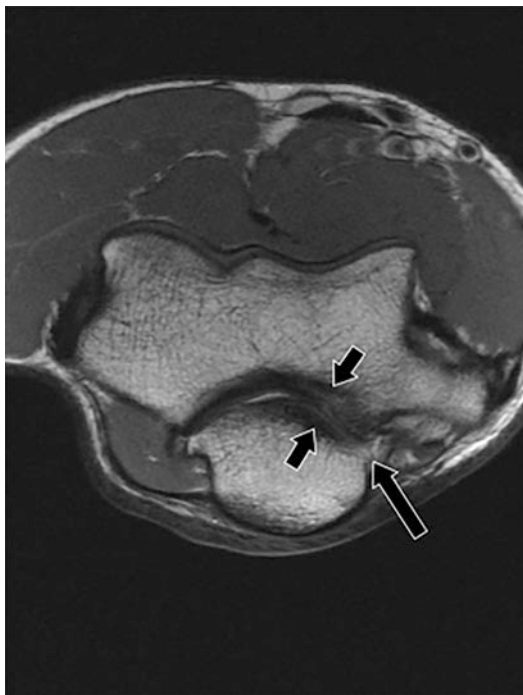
Axial FSE MR image demonstrating features of posteromedial impingement in the setting of chronic valgus extension overload. The *short arrows* indicate subchondral sclerosis, chronic bony remodeling, and partial cartilage wear in the posteromedial humeroulnar compartment. The *long arrow* shows a developing osteophyte off the medial aspect of the olecranon process
